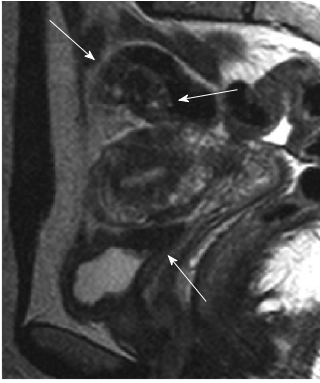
Magnetic resonance imaging shows two hypointense nodular implants of endometriosis infiltrating the proximal sigmoid wall and the utero-vesical fold, with the latter retrospectively recognized after the surgery (arrows). The presence of high signal intensity foci within the nodules is due to hemorrhagic foci.
